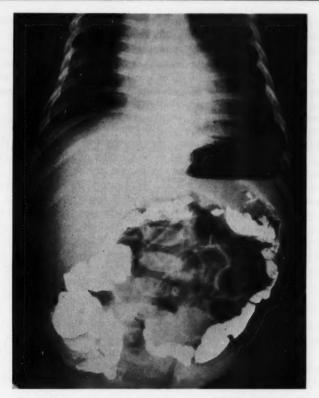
Roentgenographic view of the abdomen and chest revealing barium distributed throughout the colon and a small amount in the distal ileum. There is no definite evidence of chest pathology although there is an early infiltrative lesion in the right cardiohepatic angle.
